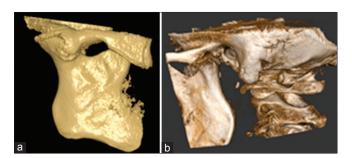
(a) Cone-beam computed tomography showing right condylar head fused to glenoid fossa, and hypertrophied coronoid process. (b) Left side showing fractured articular surface, narrowing of joint space and irregularity in the articular surface of the condyle
